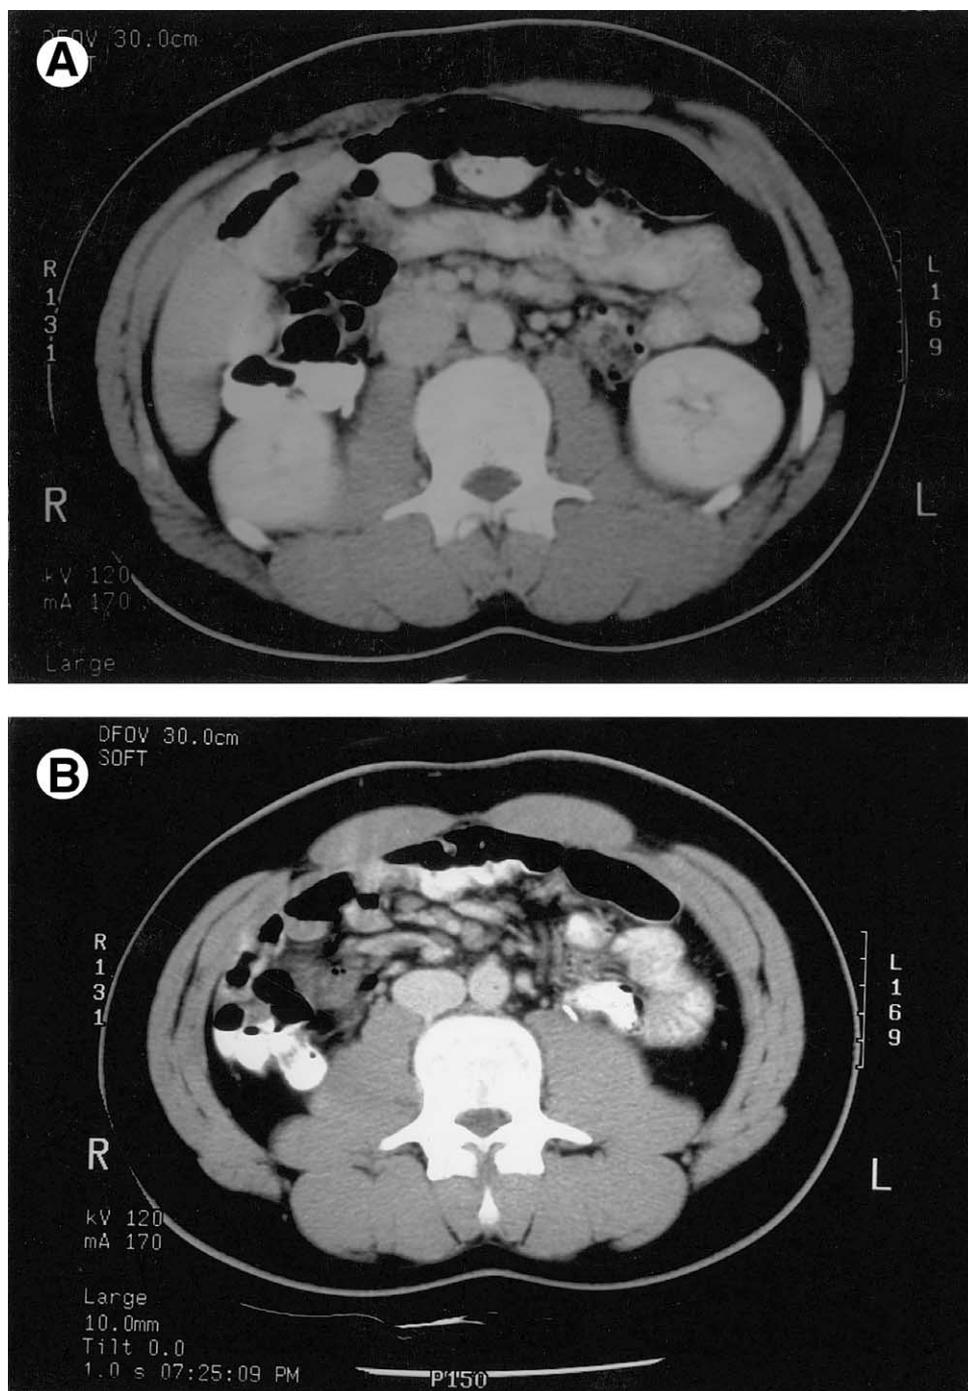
(A) Intravenous contrast helical computed tomography scan at the upper lumbar level reveals normal thickness of psoas muscle. (B) The same computed tomography scan over the L<sub>3</sub>/L<sub>4</sub> level demonstrates bulky hypertrophied psoas muscles without intra- or retroperitoneal lesions.
